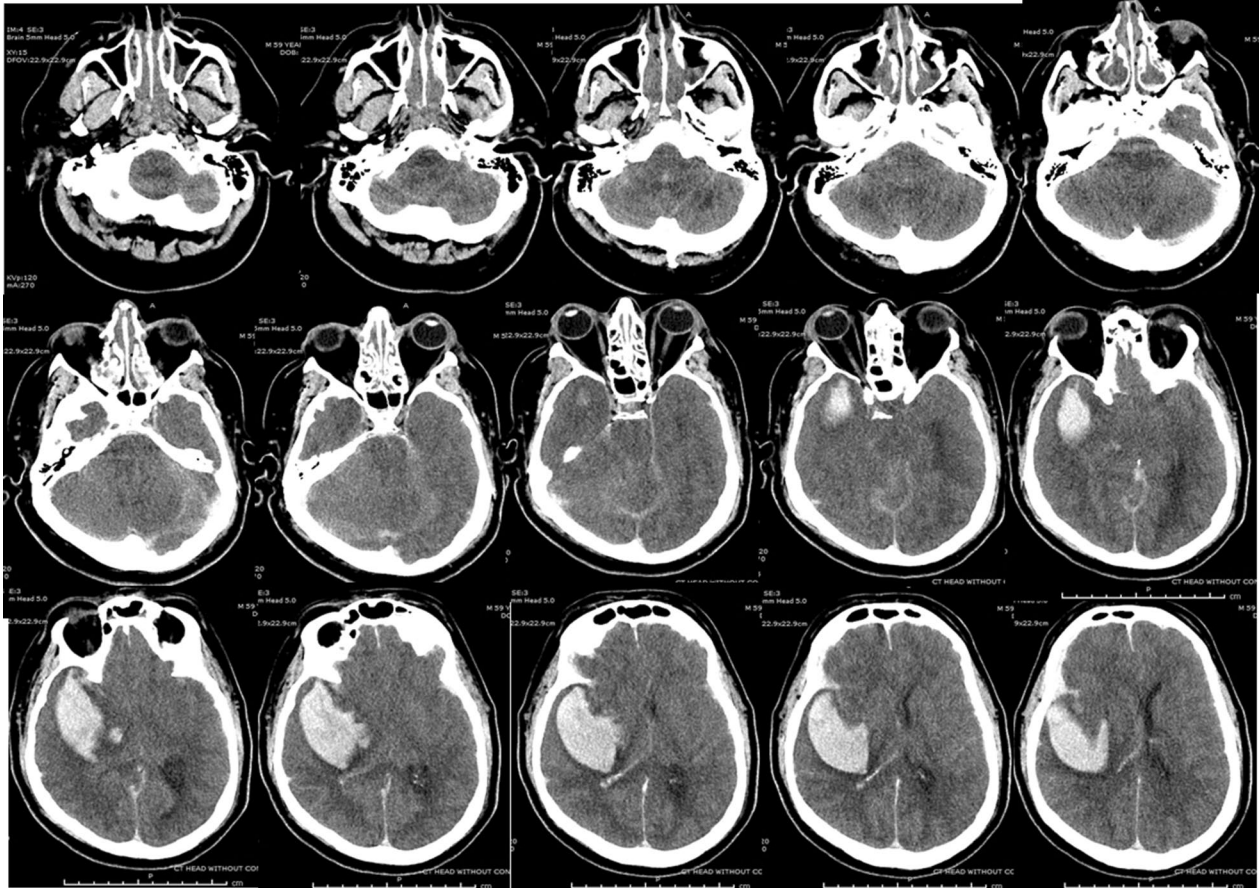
Follow-up CT scan (17 h after event) A noncontrast CT brain obtained 17 h from last known well showing the large intraparenchymal hematoma along the right temporal and insular region, with compression of the lateral ventricle, midline shift causing leftward subfalcine herniation. Both transtentorial and tonsillar herniations were present
